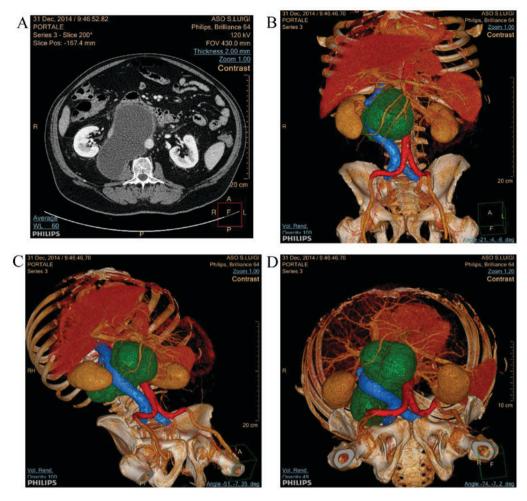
Retroperitoneal lesion. (A) Computed tomography scan; (B-D): Three-dimensional rendering of the retroperitoneal lesion (green) at different angles, showing clear dislocation of the vena cava.
